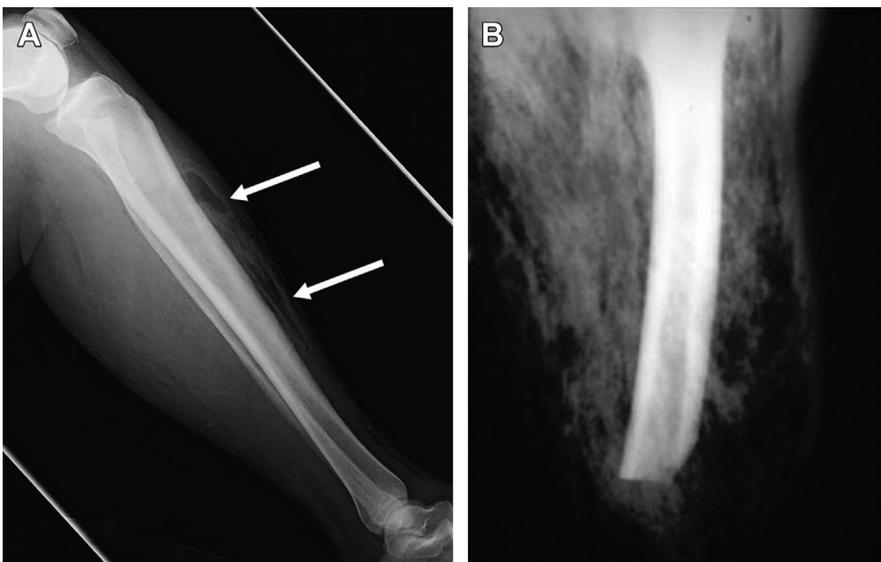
(A) Evidence of GAS tracking (arrows) on the fascia on radiograph in a patient with NSTI involving the leg. (B) Subcutaneous emphysema on radiograph in a patient with NSTI of the thigh. ([A] Data from Chaudhry A, Baker K, Gould E, et al. Necrotizing fasciitis and its mimics: what radiologists need to know. *AJR* 2015;204:128–39; and [B] From Sarani B, Strong M, Pascual J, et al. Necrotizing fasciitis: current concepts and review of the literature. *JACS* 2009;208(2):282; with permission.)
